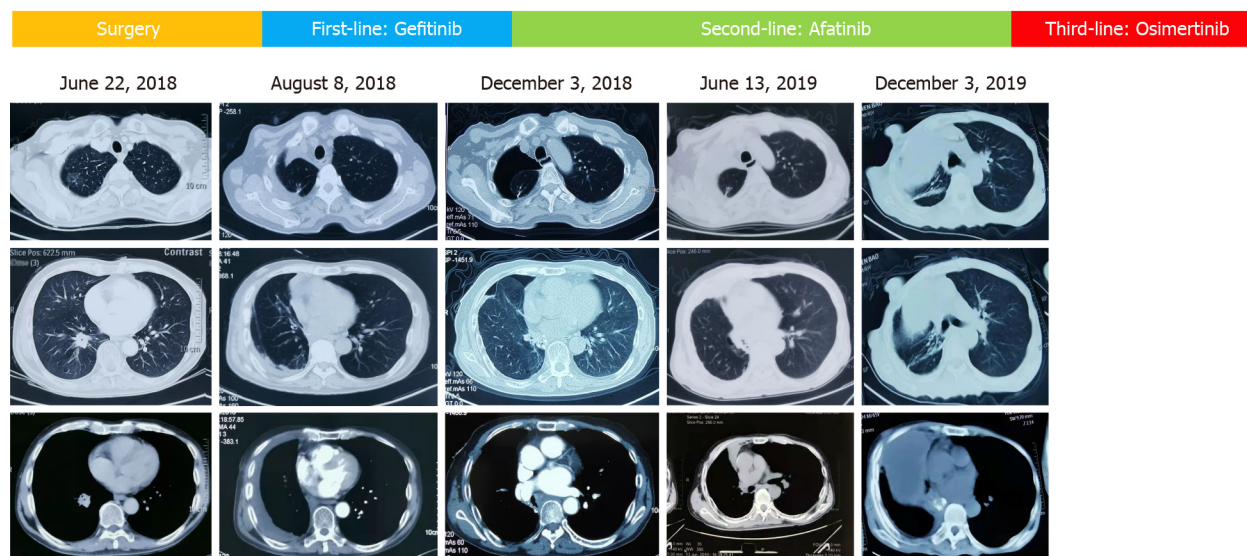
Treatment course of non-small cell lung cancer with sequential epidermal growth factor receptor tyrosine kinase inhibitor regimen with serial chest computed tomography scanning. June 22, 2018, a nodular density shadow in the lower lobe of the right lung, approximately 2.0 cm × 2.7 cm in size, and a ground-glass shadow in the upper right lung lobe, approximately 2 cm × 1.5 cm in size; August 8, 2018, postoperative changes and pleural effusion in the right lung; December 3, 2018, pleural effusion absorbed in the right lung after targeted therapy; June 13, 2019, encapsulated effusion in the right pleural cavity; December 3, 2019, encapsulated effusion increasing in the right pleural cavity. EGFR: Epidermal growth factor receptor; TKI: Tyrosine kinase inhibitor; cfDNA: cell free DNA; NGS: Next-generation sequencing.
